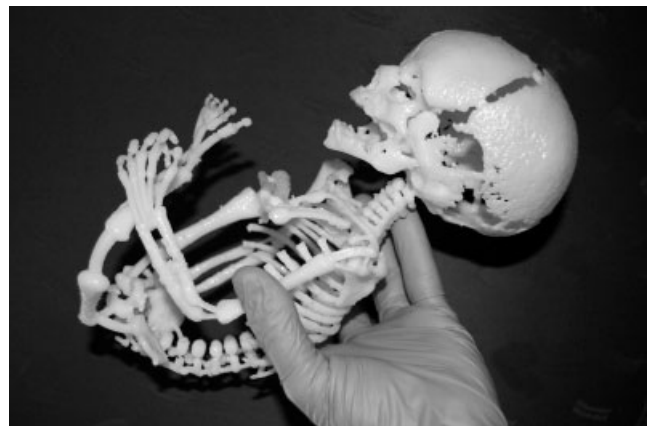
Rapid prototyping model of the skeleton of a fetus created using stereolithography after computed tomography at 35 weeks.
